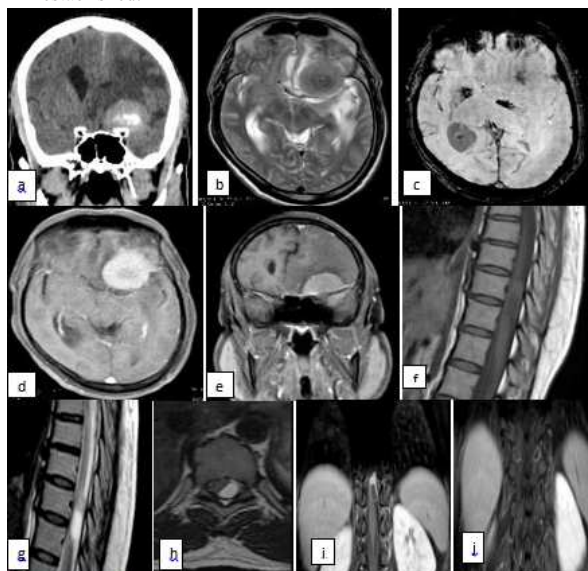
Coronal reformat CT brain images (a) showing meningioma likely arising from left anterior clinoid process of sphenoid bone.
